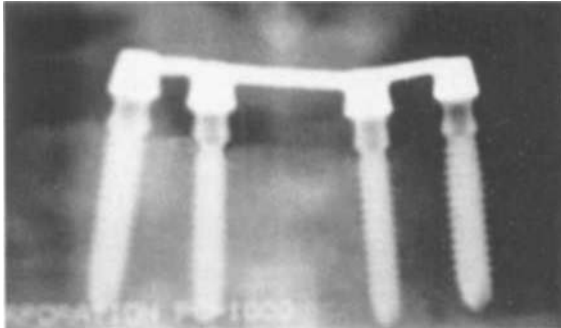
■ Radiographic check of abutment seating and splinted clip bar assembly.
